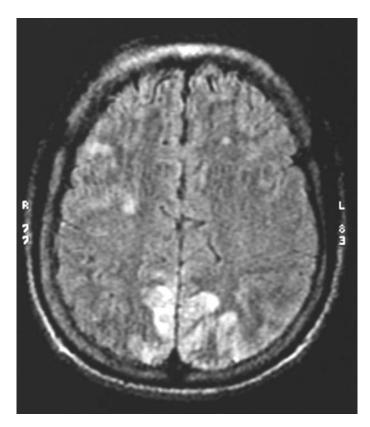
MRI of brain of an adolescent patient with hypertensive encephalopathy. Occipital area shows increased signal suggestive of edema (white area).
